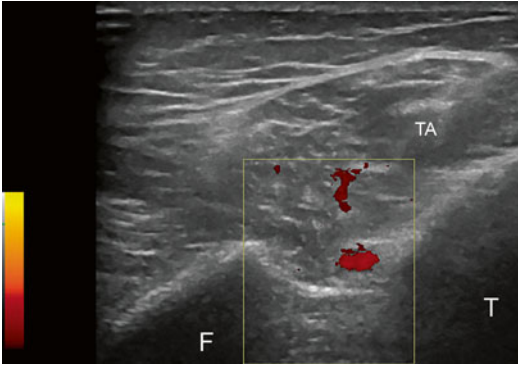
US axial scan at the proximal third of the leg. Power Doppler is useful to identify the anterior tibial artery at the level of the interosseous membrane. TA tibialis anterior muscle, T tibia, F fibula
